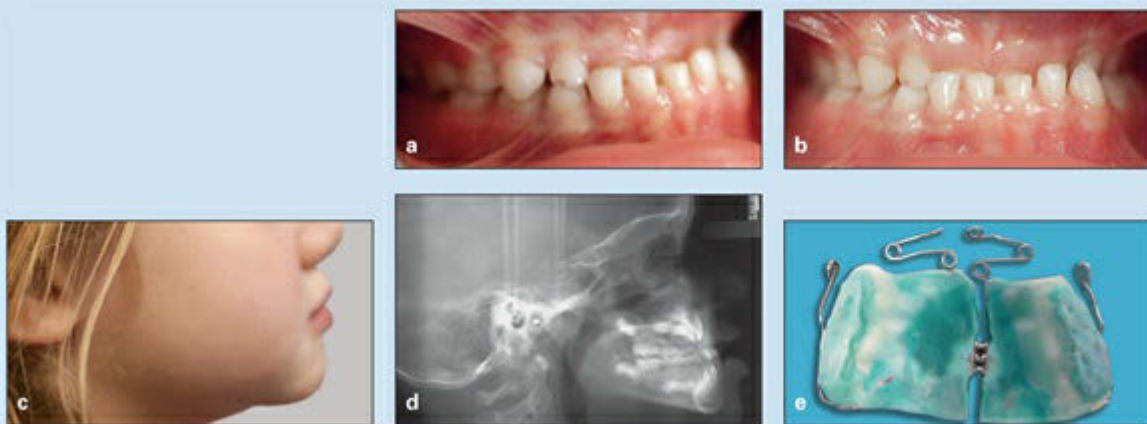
Early treatment of anterior and posterior crossbite in a 6-year-old girl. (a and b) Pretreatment occlusion. (c) Pretreatment soft tissue profile. (d) Pretreatment cephalometric radiograph. (e) Appliance used in treatment.
